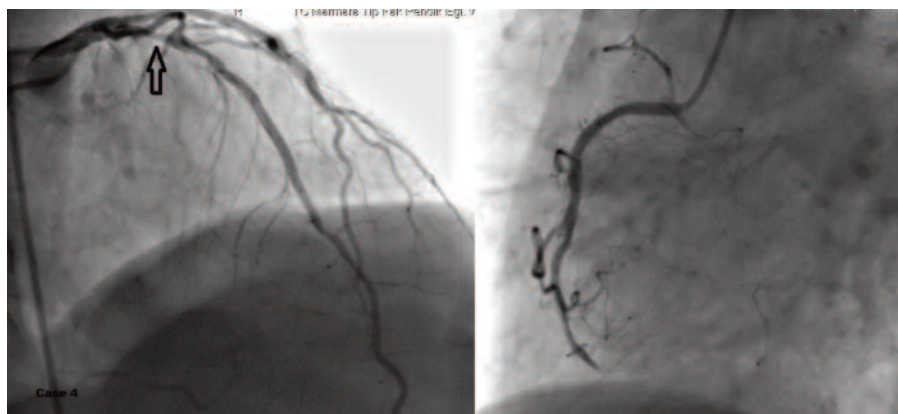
A 52-year-old male with a history of diabetes mellitus for 5 years admitted to our hospital. Echocardiographic examination revealed left ventricular wall-motion abnormality in the inferior segments. Myocardial perfusion scintigraphy examination demonstrated reversible ischemia and infarct at the inferior wall. Total occlusion at the mid-level of the RCA with well-developed collateral supply from the LAD with an intermediate proximal stenosis (arrow) was detected by coronary angiography. Initial and final FFR values were 0.68 and 0.78, respectively.
